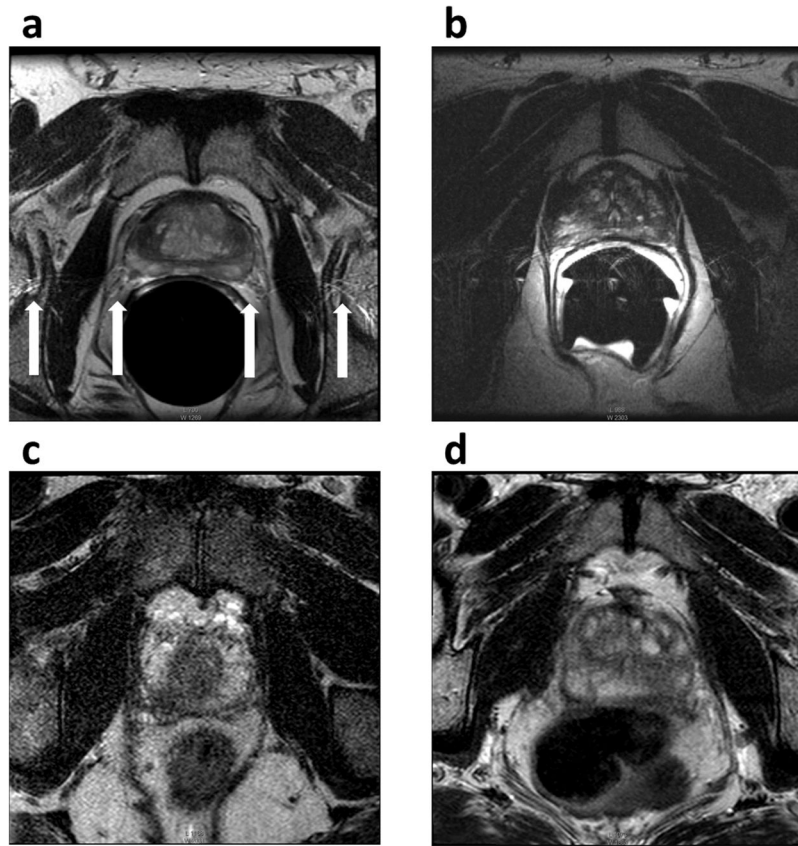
Image artifacts on 1.5 T endorectal and 3.0 T MRI. The typical image artifacts from 1.5 T endorectal MRI included ghosting (a) and coil-related SNR decrease (b). The typical artifacts from 3.0 T MRI are signal graininess (c) and rectum motion artifact (d).
